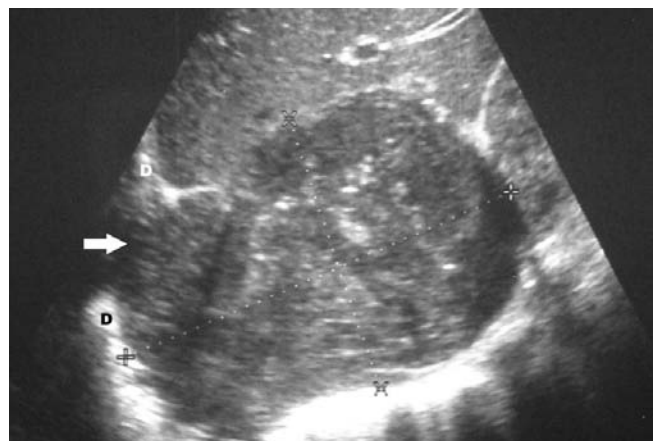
Sagittal ultrasound scan of the right lobe of liver demonstrating a mixed echogenicity mass in segments 7 and 8, with an associated defect (arrow) in the right hemidiaphragm (D).
